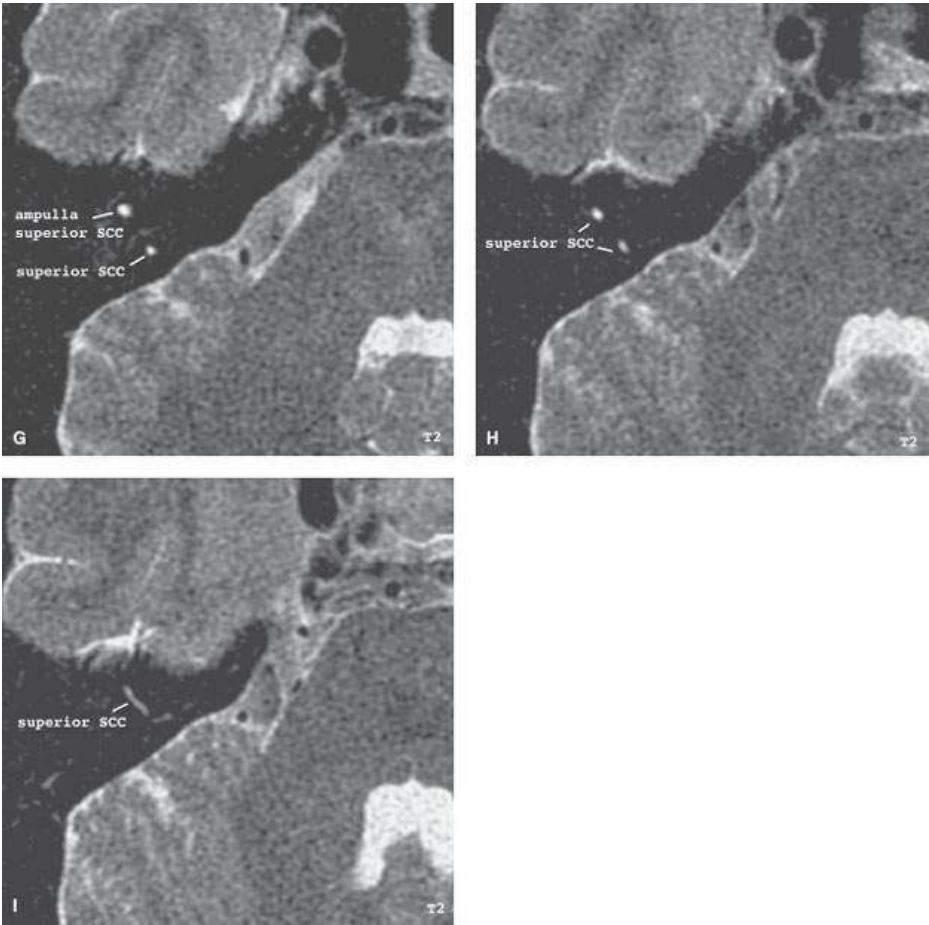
A–E: Axial T2-weighted magnetic resonance images of the normal anatomy of the inner ear.
